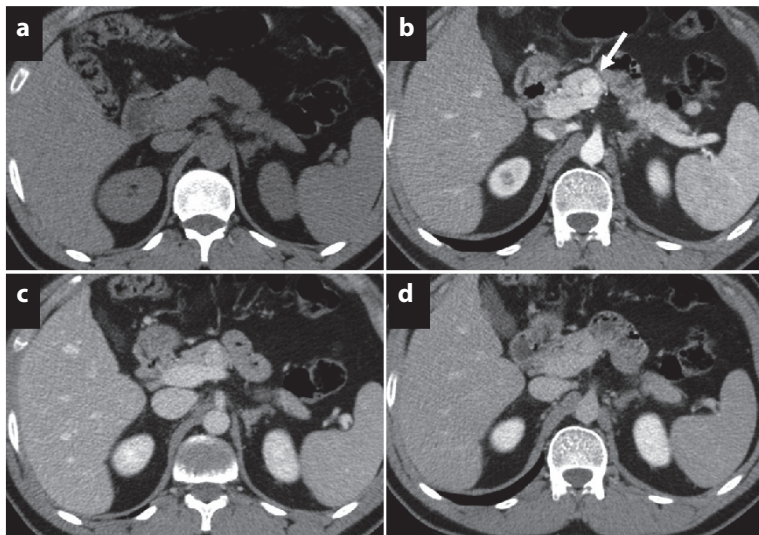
CT features of a functioning P-NET. Axial contrast-enhanced CT images acquired in a 36-year-old man show pancreatic insulinoma (*arrow in b*) with typical imaging features: small size (12 mm) and avid enhancement (brighter than normal surrounding pancreatic parenchyma in the arterial phase). During the portal (c) and equilibrium phase (d) the lesion appears isodense compared to the surrounding parenchyma
